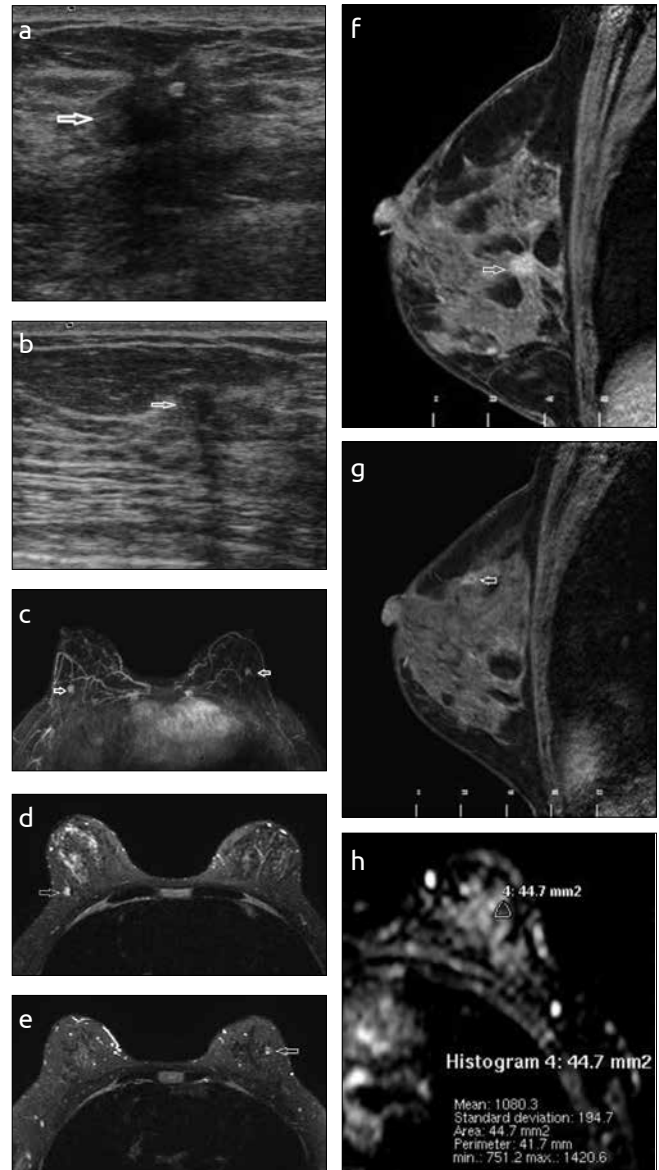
a-i (mass 7 and mass 8). A 48-years-old woman with bilateral tubular carcinoma that was negative on MG. Sonography detected an irregular shaped mass with spiculated margins on the right breast (a) and irregular shaped mass with indistinct margins on the left breast (b). Axial maximum intensity projection of a contrast enhanced T1-weighted three-dimensional spoiled gradient-echo image (c) shows bilateral tubular carcinomas (arrows). Axial T2-weighted with fat suppression images show 9mm hyperintense mass with slightly visible internal septation on the right breast (arrow) (d) and 7 mm hyperintense mass with prominent hypointense internal septation on the left breast (e). In the sagittal plane of post-contrast fat suppression images, mass on the right breast enhanced homogeneously (arrow) (f) and mass on the left breast enhanced heterogeneously (arrow) (g). Apparent diffusion coefficient (ADC) map reveals $1.12 \times 10^{-3} \text{ mm}^2/\text{s}$ within mass on the right breast (h) and $1.08 \times 10^{-3} \text{ mm}^2/\text{s}$ on the left breast (i)
